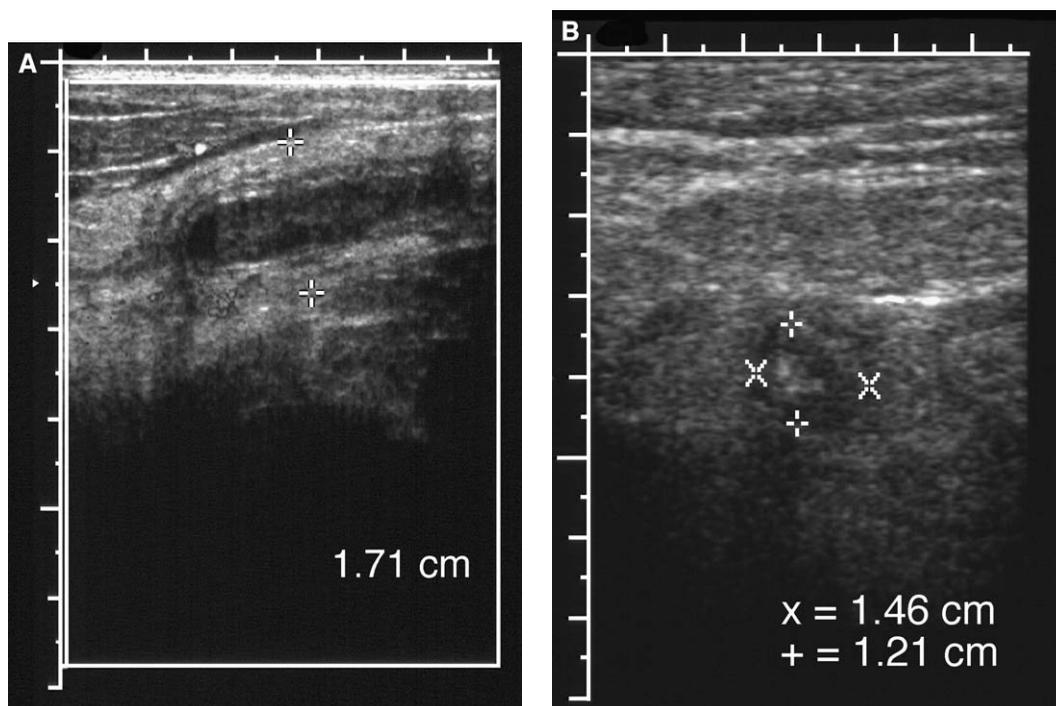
Acute appendicitis. Longitudinal (A) and transverse (B) ultrasound images show an inflamed appendix (between the calipers), which is enlarged.
